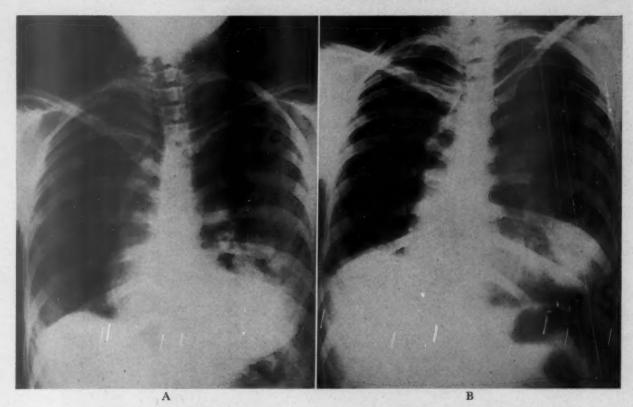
Case 25. X-ray films of the chest. A, pulmonary edema of high altitude is predominant in the left lung. B, at sea level two days later. Both lung fields show a more normal appearance. The patient was treated only with oxygen and 400,000 units of penicillin.
